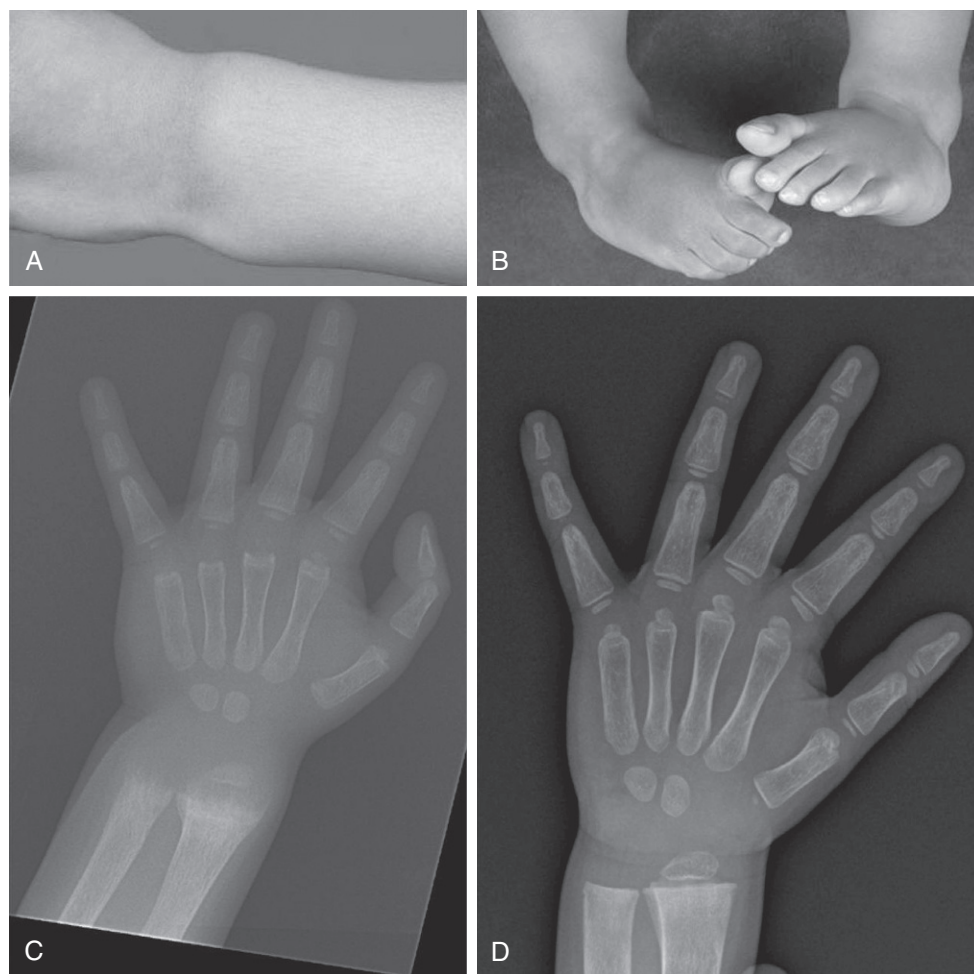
Clinical and radiographic manifestations of vitamin D-deficient rickets in a two year old child. Note flaring of the distal metaphyses of the left wrist (A) and both ankles (B), roentgenographic demonstration of widening of the metaphyses of the radius and ulna © with increased mineralization after treatment with cholecalciferol for three months (D). (From Girgis CM, Clifton-Bligh RJ, Hamrick MW, et al. The roles of vitamin D in skeletal muscle: form, function, and metabolism. *Endocr Rev.* 2013;34:33–83. Images are courtesy of Associate Professor Craig Munns, Childrens' Hospital Westmead, Sydney, Australia.)
